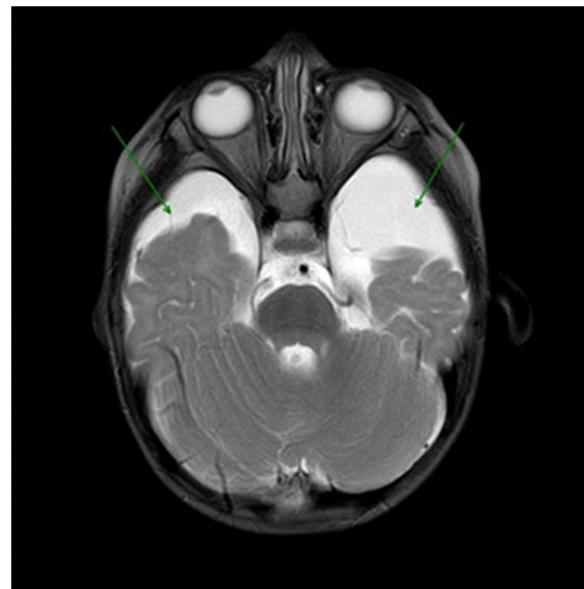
T2 axial brain MRI. Significant increase of bilateral temporal predominant subarachnoid spaces, compatible with bilateral temporal arachnoid cysts, more significant in the left side.
